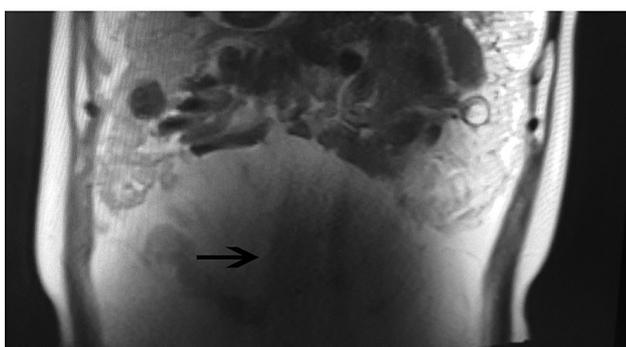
A. MRI showing a non-homogeneous mass in the uterine cavity before operation (arrow: tumor). B. MRI demonstrated a large cyst-solid mixed abdomino-pelvic mass, which suggests tumor recurrence at 17 months postoperation (arrow: recurrent tumor).
